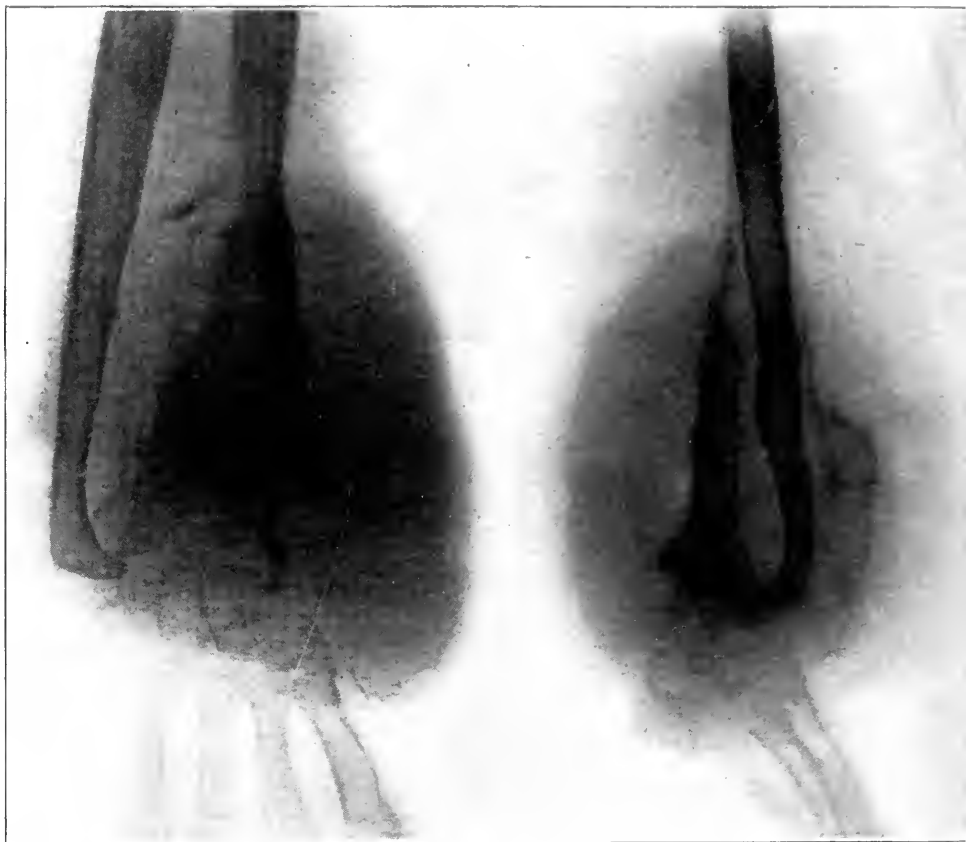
(Case 1).—Roentgen-ray appearance of growth shown in Figure 2. There is bone destruction and new bone formation, suggestive of osteogenic sarcoma.
